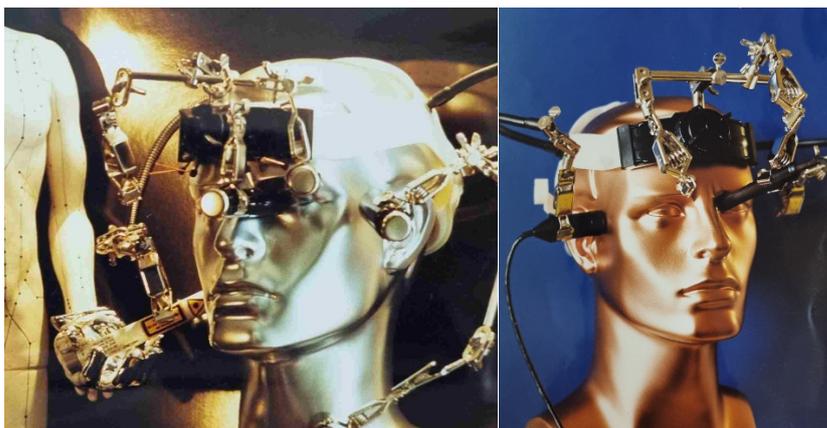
Simultaneous ultrasonic blood flow measurements in different cerebral arteries using a helmet construction developed in Graz in 2001 (© Gerhard Litscher).
